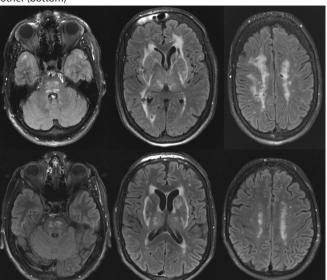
Fluid attenuated inversion recovery (FLAIR) MRI of the homozygous patient (top) and her heterozygous brother (bottom)
